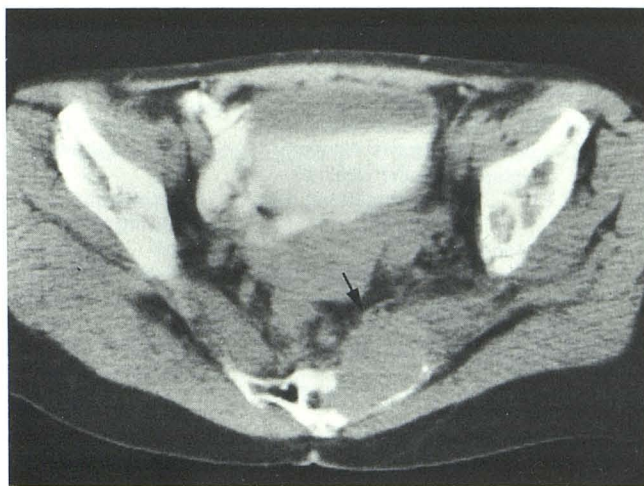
Case 5: left-sided sciatica after nephrectomy for Wilms tumor. CT demonstrates mass destroying left side of sacrum and extending into GSF (arrow) to involve sacral plexus.
